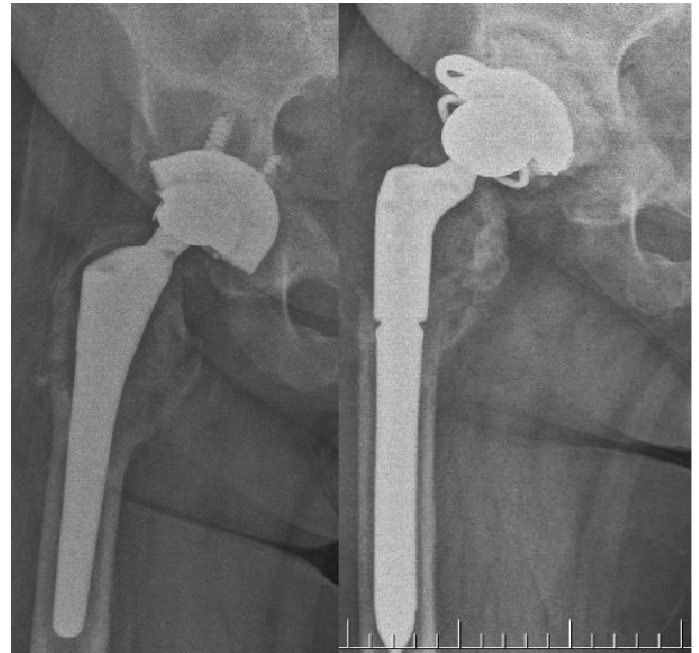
Preoperative and postoperative radiographs of the Case 1 revealing periprosthetic osteolysis and asymmetric thinning of the metal femoral head, also metal corpora libera originating from the metal head is lying adjacent to the lateral border of the head.
